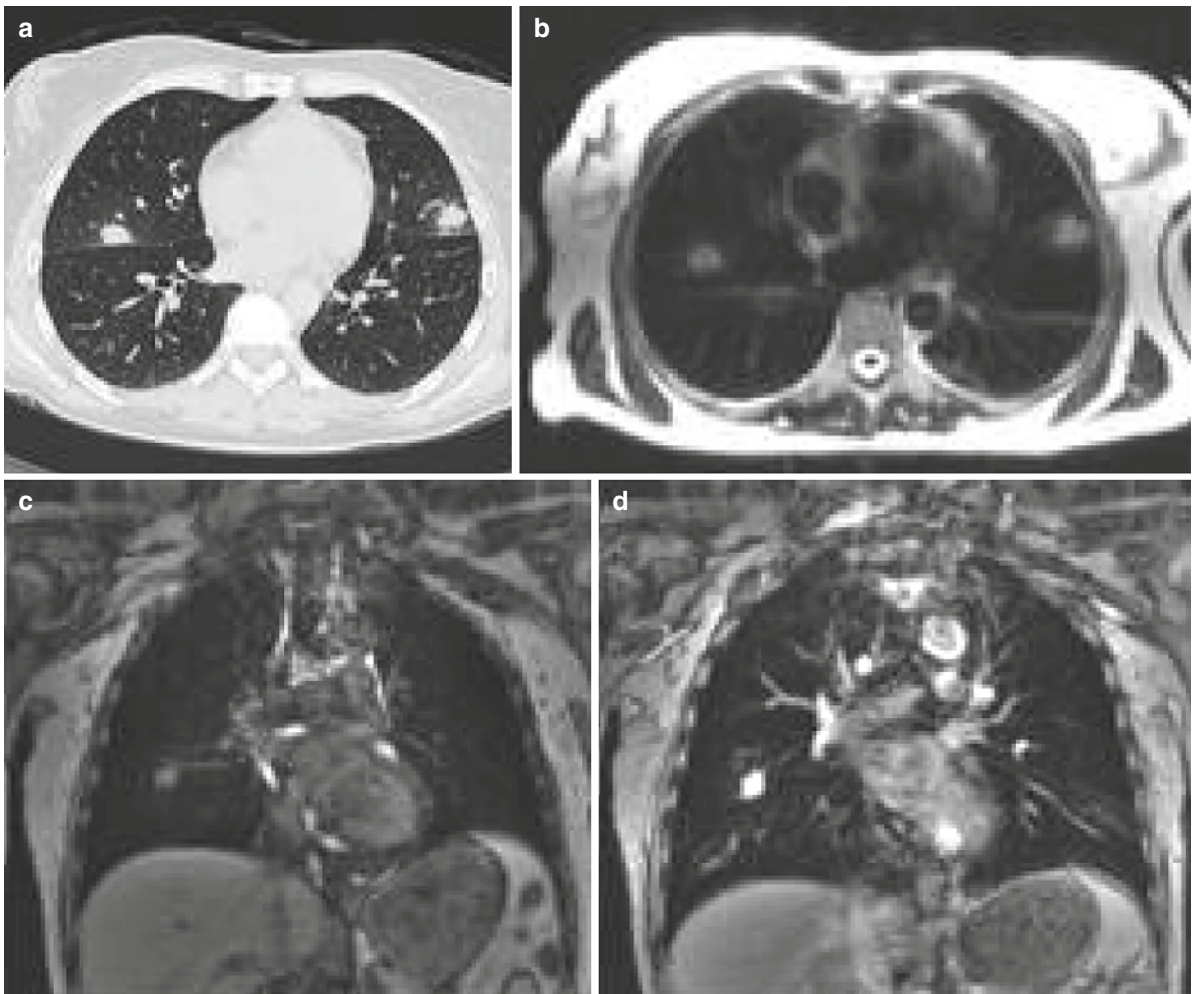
Fungal pneumonia. Same-day HRCT and MRI. (a) HRCT findings. (b) MRI, T2-weighted sequence. (c) MRI, non-enhanced T1-weighted gradient-echo sequence. (d) Post-gadolinium MRI. Lesion contrast is similar by CT and contrast-enhanced MRI
